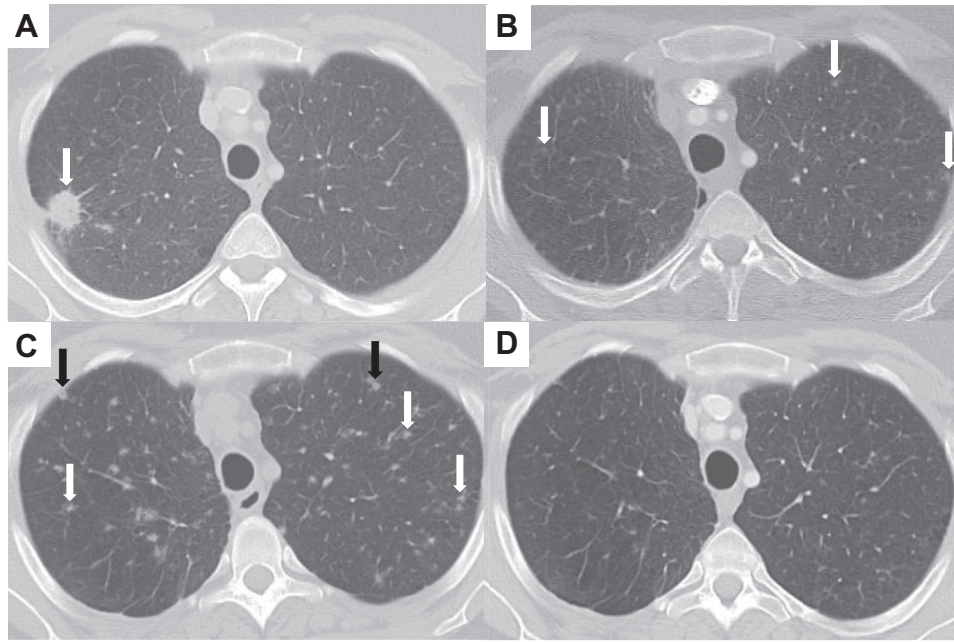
CT scan of the chest. (A) The patient's right upper lobe lesion (arrow) was noted on initial presentation. (B) Two months after wedge resection of the patient's primary tumor, the imaging result revealed the development of bilateral pulmonary nodules (arrows), predominantly in the upper lobes of the lungs. (C) A repeat CT scan 3 months after the surgery revealed increased size and density of these irregular nodules (arrows), which are somewhat centrilobular in distribution; some nodules had cavitation (black arrows). (D) Imaging 4 months after the diagnosis of LCH revealed a decrease in size and density of these nodules. CT, computed tomography; LCH, Langerhans cell histiocytosis.
